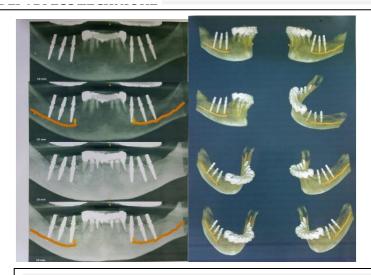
POSTOPERATIVE CBCT AFTER PLACEMENT OF IMPLANTS
